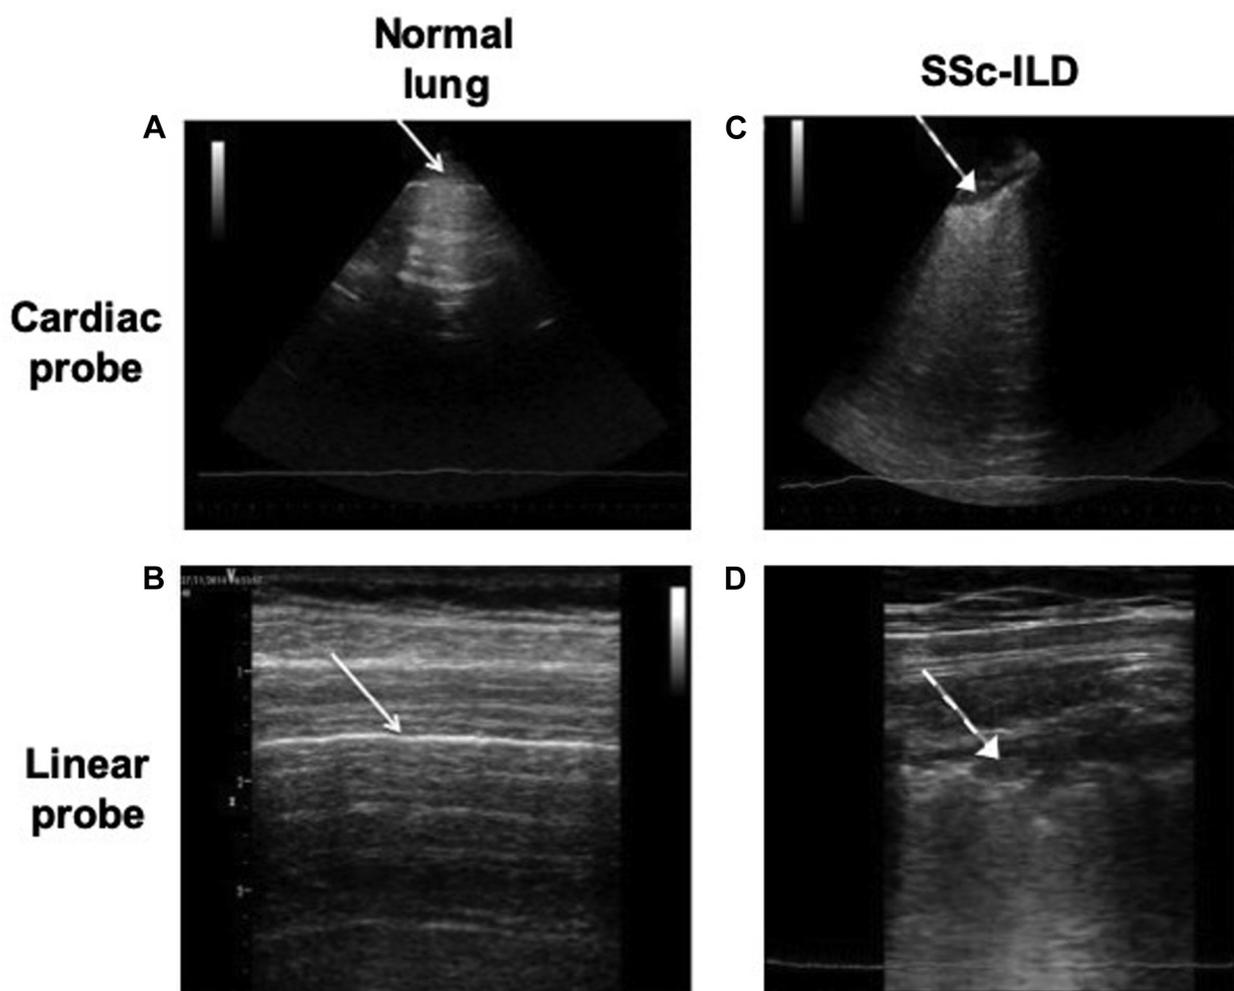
Normal lung ultrasound pattern (A, cardiac probe and B, linear probe) compared with interstitial lung disease pattern (C, cardiac probe and D, linear probe). The white arrows in A and B indicate the normal pleural line; the dotted-line arrows in C and D indicate pleural line alterations.
